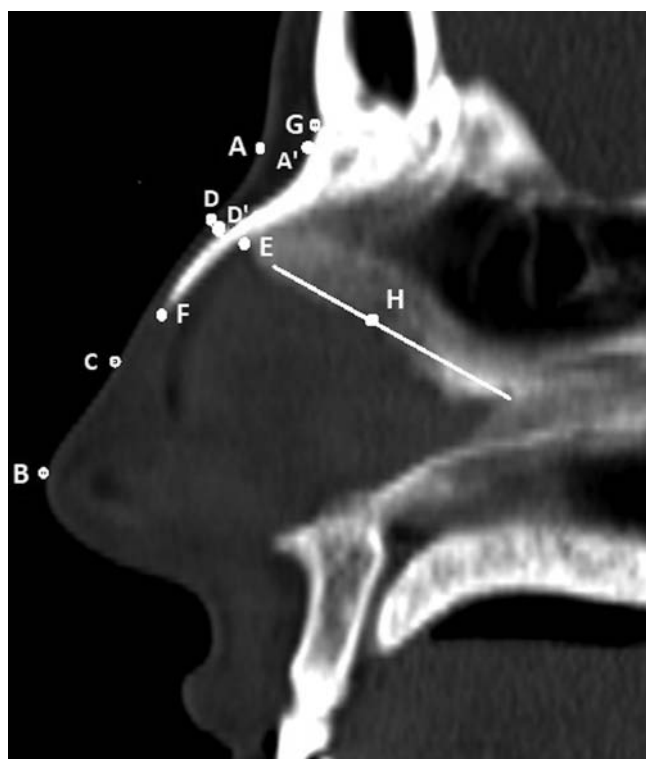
Landmarks employed for measurements on a nasal computed tomography scan of this 32-year-old male patient with a noticeable nasal hump. A, selion; B, pronasale; C, beginning of superficial nasal hump; D, ending of superficial nasal hump; C', beginning of nasal hump on bone; E, Ethmoidal point; F, Rhinion; G, nasion; H, Ethmoidal axis point.
